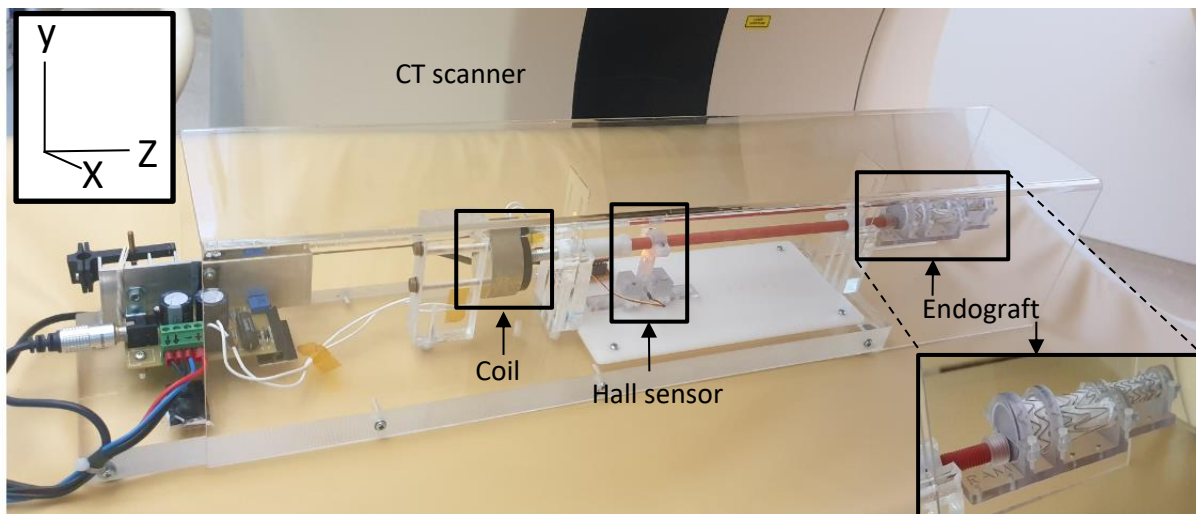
Experimental set up. *The coil of the linear actuator provided a linear movement in the z-direction. CT, computed tomography*
